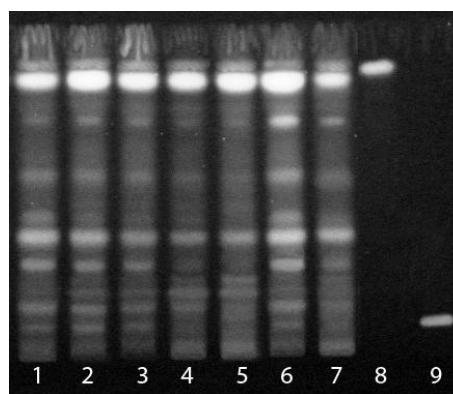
Thin-layer chromatograms of Siamese neem flower extract prepared by different methods of extraction. 1 = Maceration, 2 = Percolation, 3 = Soxhlet extraction, 4 = Ultrasonic extraction with 50% ethanol, 5 = Ultrasonic extraction with distilled water, 6 = Decoction, 7 = Microwave assisted extraction, 8 = Quercetin, 9 = Rutin. Absorbent: Silica gel G60 F₂₅₄. Solvent system: ethylacetate: dichloromethane: formic acid: acetic acid: water 100: 25: 10: 10: 11. Detection: NP/PEG spraying reagent, under UV 366 nm
